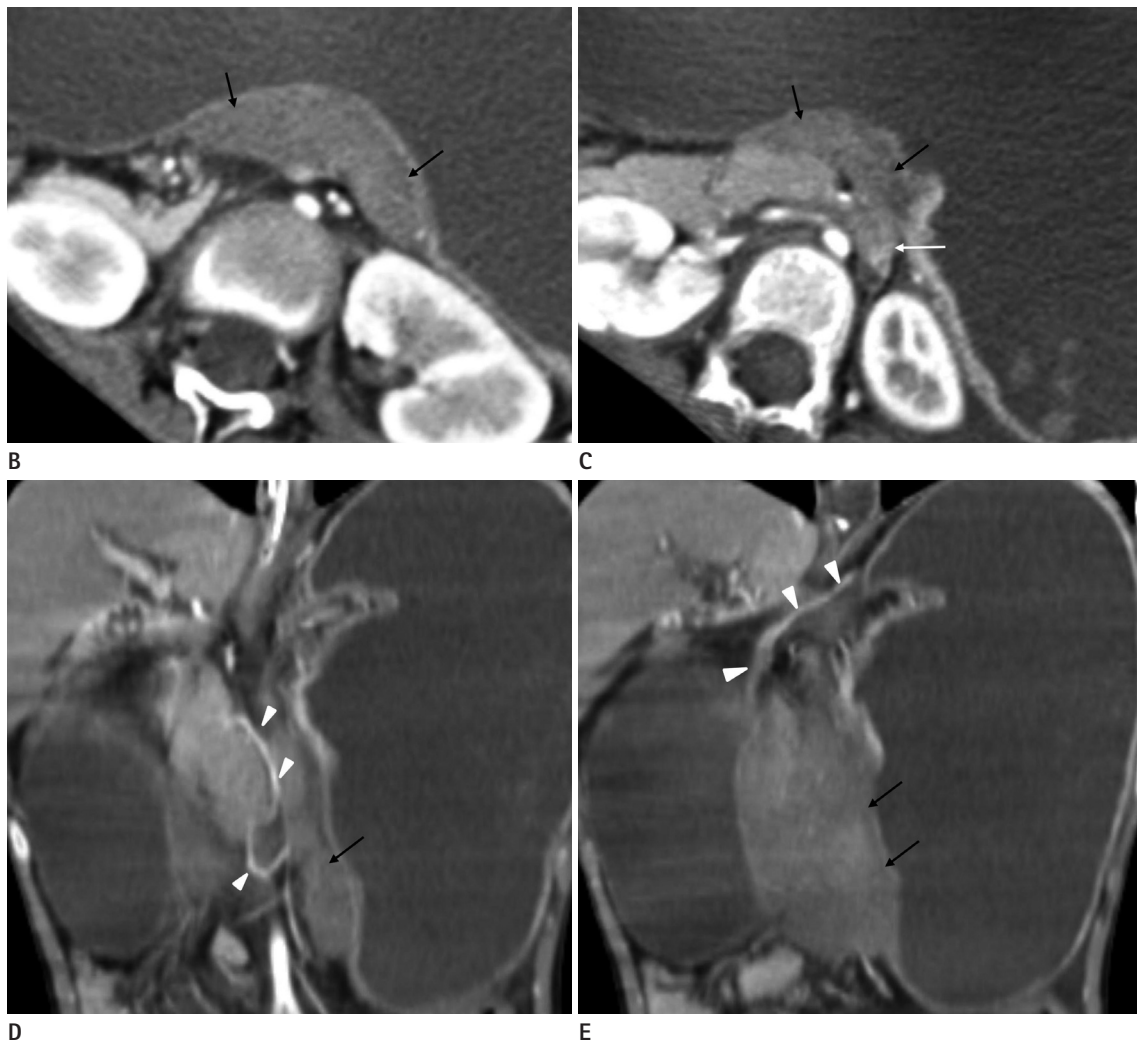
A 15-year-old girl with acute mesenteroaxial gastric volvulus, torsion of wandering spleen and intestinal non-rotation. B, C. Axial contrast-enhanced CT images reveal rotated spleen in counter clockwise direction resulting in decreased perfusion (black arrows in B and C). The spleen is observed anteriorly to the pancreas. The pancreas is medially displaced with kinking in its tail portion (white arrow in C). D, E. Coronal reformatted CT images show that the splenic artery (arrowheads in D) from celiac trunk is twisted in counter clockwise direction. The hypoattenuated spleen is located in the midline of upper abdomen (black arrows in D and E). The right gastroepiploic artery (arrowheads in E) runs superomedially. The upside-down positional change of the right gastroepiploic artery as a vascular landmark of the gastrocolic ligament is also noted.
